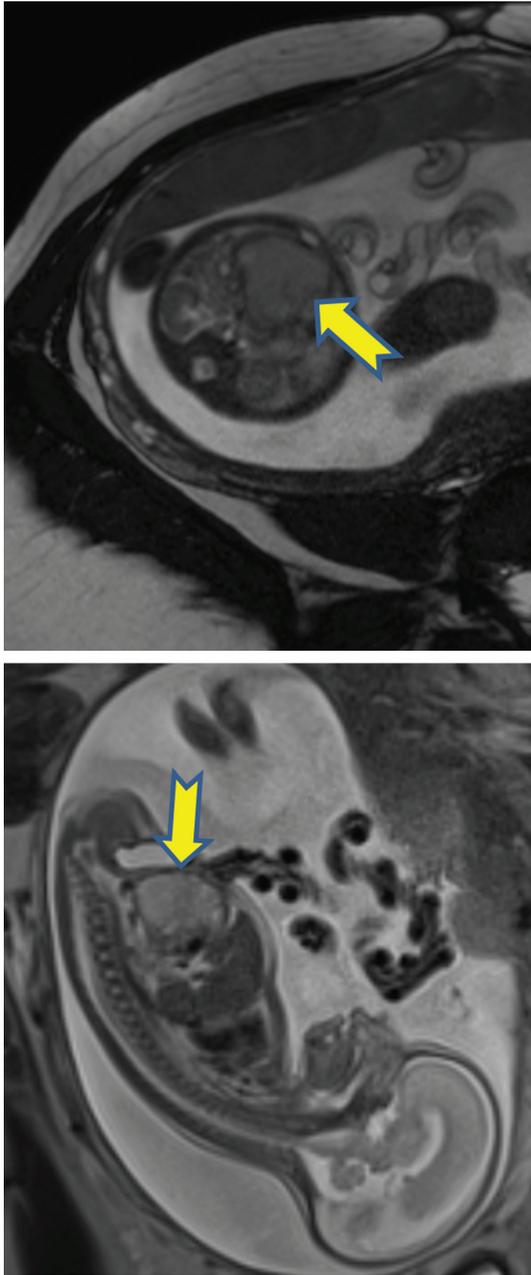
Magnetic resonance imaging T2-weighted images at 24 weeks of gestation showed a 30×29×22 mm cystic mass with internal septations and calcifications at umbilical cord entry level of fetal lower abdomen which was evaluated as meconium pseudocyst
